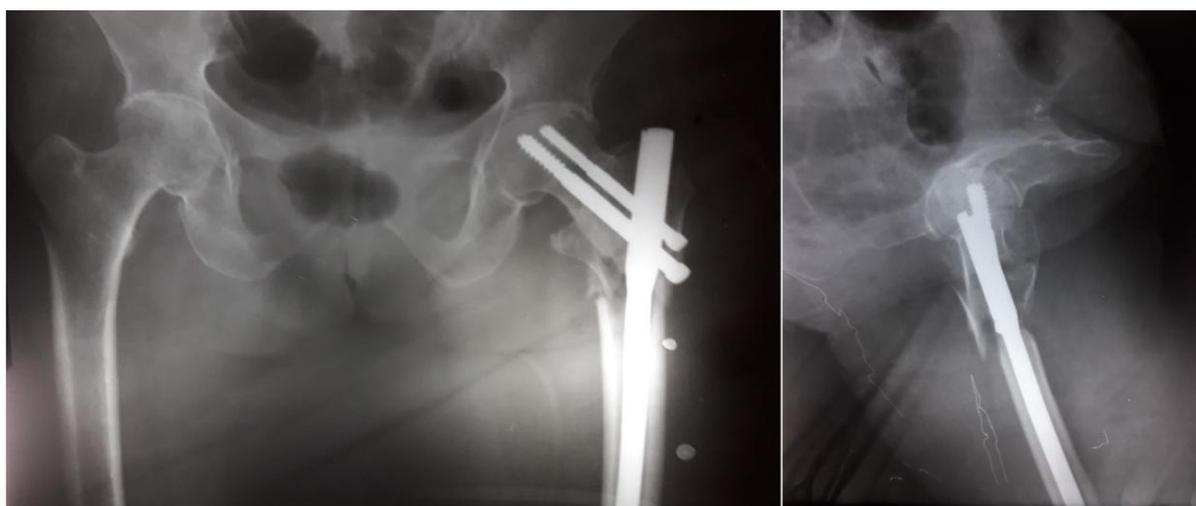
X-ray showing post operative AP and lateral view of PFN.
